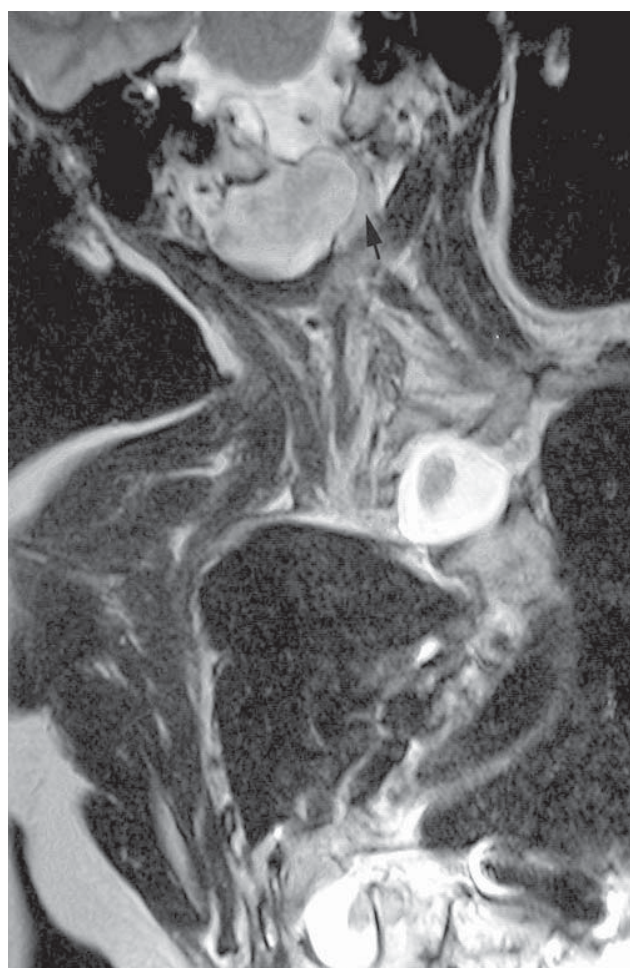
Coronal T2W MRI in the cervicothoracic region showing a dumb-bell neurofibroma compressing the cervical spinal cord (arrow)
